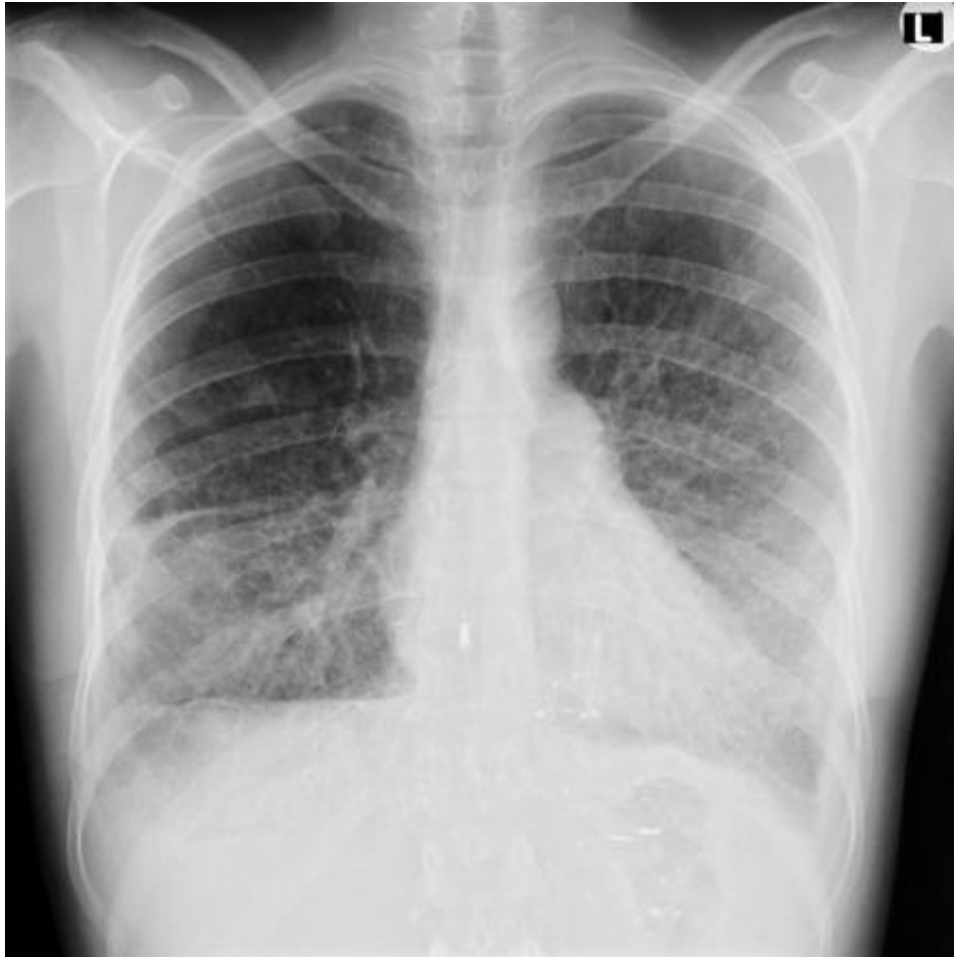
Chest radiograph in advanced lymphangioleiomyomatosis showing a combination of left pneumothorax, interstitial changes and pleural shadowing due to a chylothous effusion.
